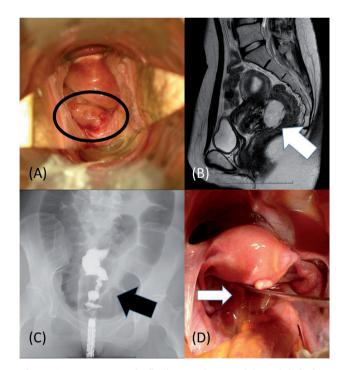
Macroscopic findings and MRI of the pelvis before treatment. A) The polyp is protruding from the posterior vaginal fornix (circle). B) Sagittal T2 weighted MRI show a hyper-intense signal mass located at Douglas' pouch extending from the posterior vaginal wall to the rectum (arrow). C) 'Apple-core' stenosis by barium enema examination. D) Intraoperative image. The mass arises at the Douglas pouch (arrow), and involves uterine cervix, rectum, and bilateral cardinal ligament.
